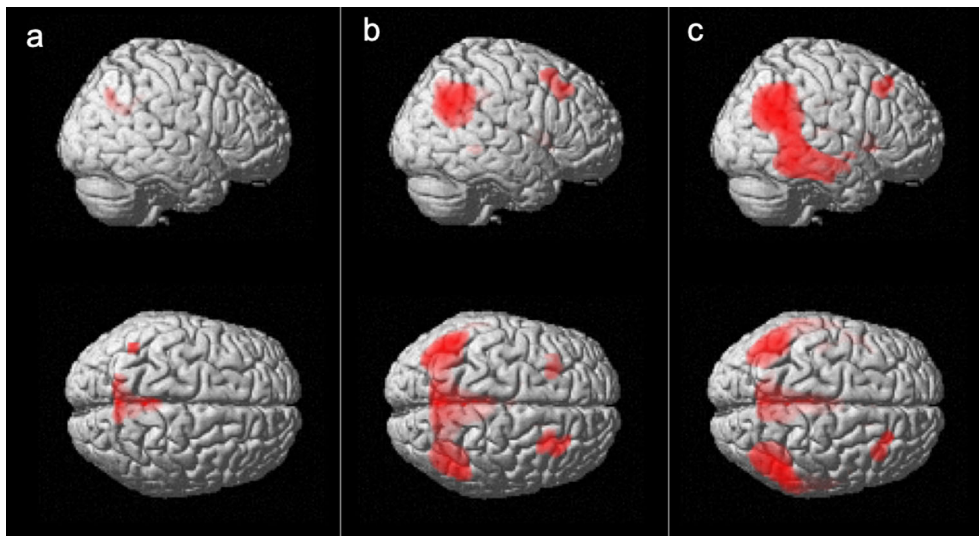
Areas of significant hypometabolism in AD-noBPSD, AD-BPSDdeveloper, and AD-BPSD as compared to controls. (a) AD-noBPSD: PCC, precuneus, bilateral medial temporal and parieto-temporal cortices; (b) AD-BPSDdeveloper: PCC, precuneus, bilateral medial temporal and parieto-temporal cortices, superior temporal gyri and left parahippocampal gyrus; (c) AD-BPSD: PCC, precuneus, bilateral medial temporal and parieto-temporal cortices, and bilateral superior, middle, and inferior temporal gyri. AD, Alzheimer's disease; BPSD, behavioural and psychological symptoms of dementia; FDG-PET, ^{18}F -fluorodesoxyglucose-positron emission tomography; AD-noBPSD, AD patients without BPSD; AD-BPSD, AD patients with BPSD at the time of FDG-PET; AD-BPSDdeveloper, AD patients who developed BPSD after FDG-PET; PCC, posterior cingulate cortex.
